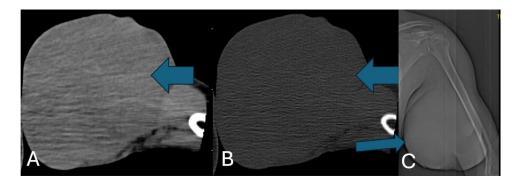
Axial nonenhanced computed tomography scan of soft tissue (A) and bone window (B) and scanogram (C) of the left arm demonstrated a well-defined, heterogeneous density mass lesion within the subcutaneous tissue with few hypodense cystic/necrotic areas, without invasion into deeper muscle layers.
